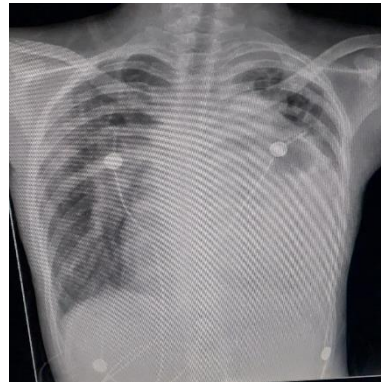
Chest X-Ray demonstrated right atrial enlargement and right ventricular hypertrophy, pulmonary hypertension features, increasing bronchovascular, infiltrate in both upper lungs
